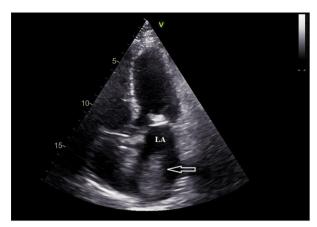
Transthoracic echocardiography, apical four-chamber view. Intra-atrial thrombus (arrow) in the left atrium (LA).
